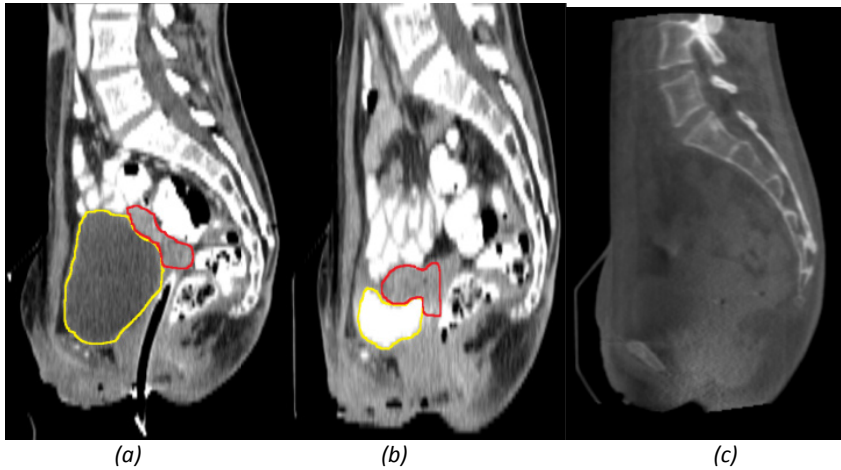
Sagittal slices of CT scans of a patient (a) with a full bladder and (b) with an empty bladder. In both CT scans, both the bladder and the uterus are delineated. Figure c shows a CBCT scan of the same patient.
